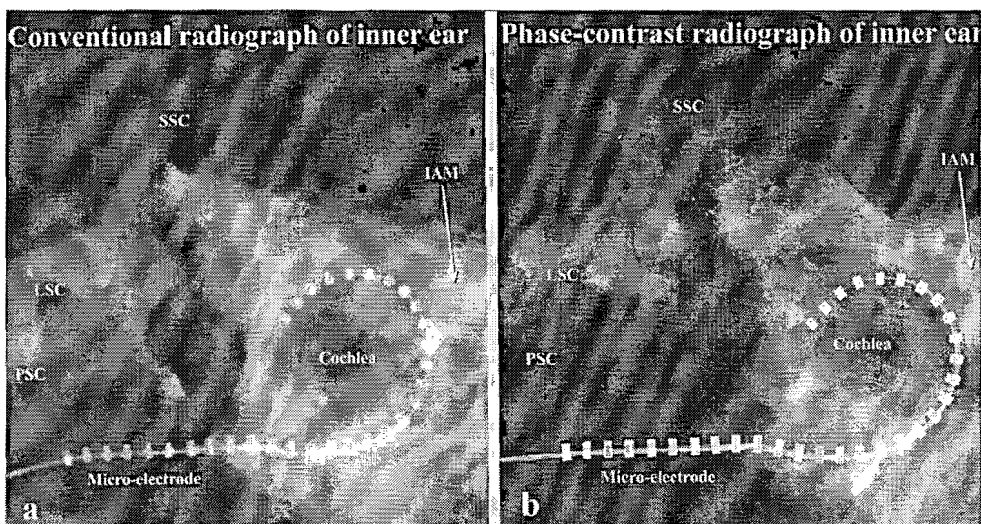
Conventional radiograph (a) and Phase-contrast radiograph (b) of the temporal bone with an experimental Nucleus standard electrode array inserted in the cochlea. SSC = superior semicircular canal; LSC = lateral semicircular canal; PSC = posterior semicircular canal; V = vestibule; IAM = internal auditory meatus.
